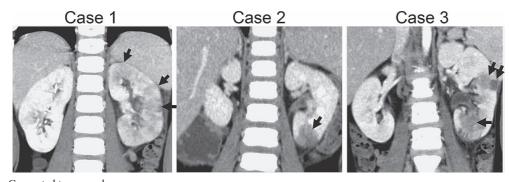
Computed tomography scan. Coronal images of enhanced CT demonstrated decreased enhancement areas (indicated by arrows) in the kidneys in all three patients.
